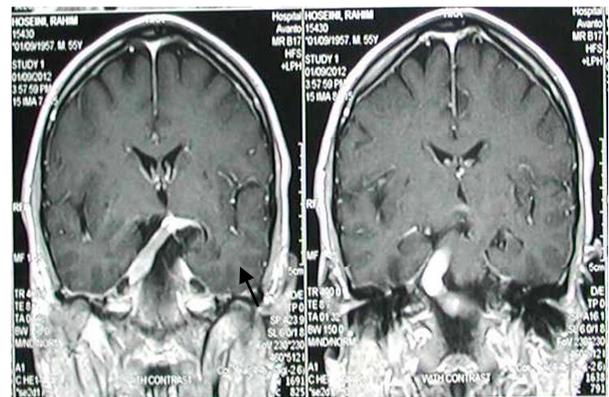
Brain magnetic resonance imaging (MRI), with contrast showing dilatation of intracranial segment of basilar artery, with extrinsic pressure over both sides of medulla
